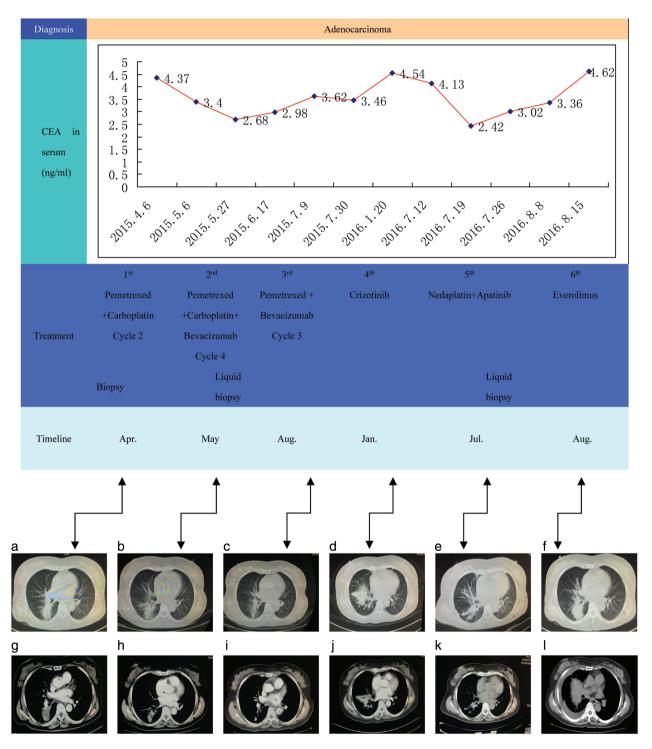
Lung adenocarcinoma treatment with different chemotherapy or target therapy regimens and results of monitoring the carcinoembryonic antigen (CEA) levels. The color-coded boxes to the left of each panel explain the relevant data. Lung computed tomography (CT) scans from (a) April 2015, (b) May 2015, (c) August 2015, (d) January 2016, (e) July 2016, and (f) August 2016. CT scans of the mediastinum from (g) April 2015, (h) May 2015, (i) August 2015, (j) January 2016, (k) July 2016, and (l) August 2016.
